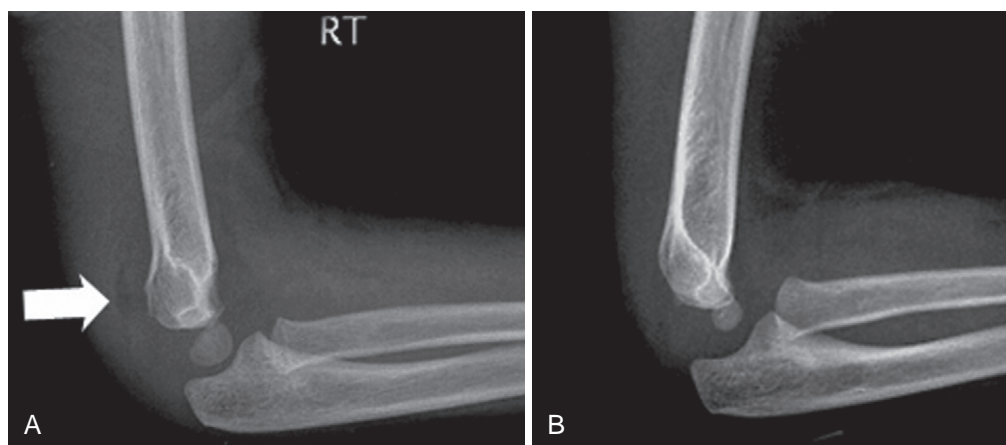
Lateral elbow radiographs of a 2-year-old boy with a mildly displaced supracondylar humerus fracture and arrow showing a posterior fat pad sign (A) and a normal age-matched elbow (B).
